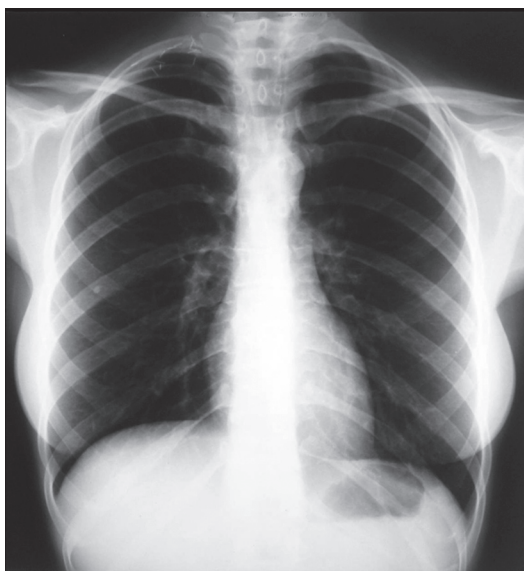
X-ray showing bilateral cervical ribs, more evident on the left (arrow) than on the right (highlight).
